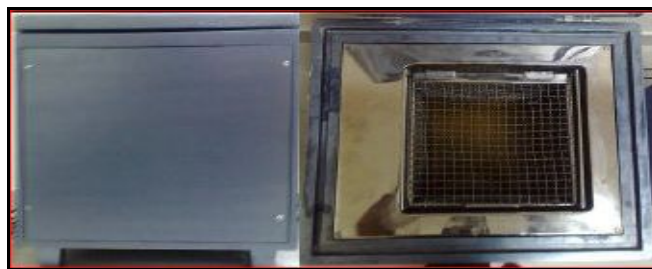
Ultrasonic generator
